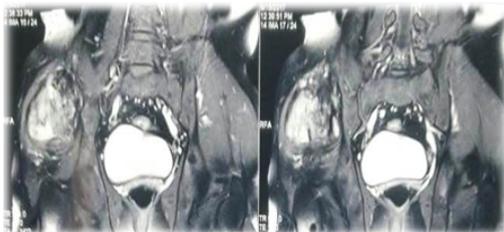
MRI of the right hip and pelvis
